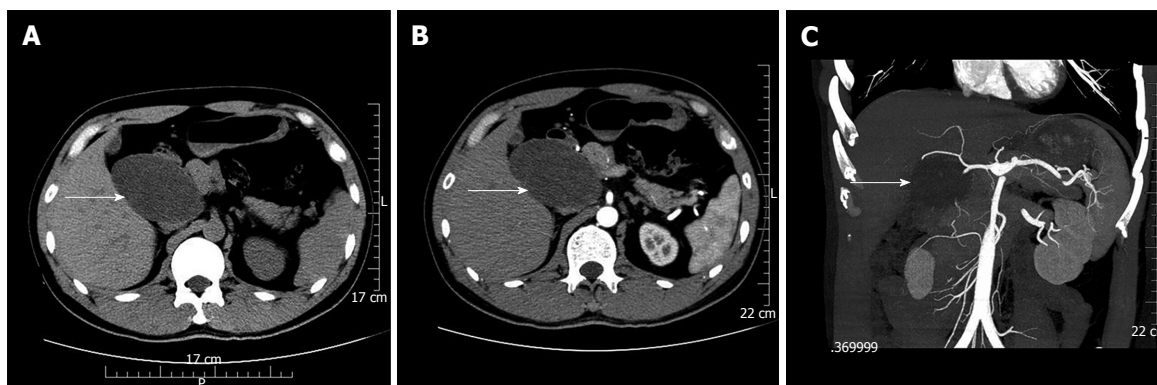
Computed tomography findings. A: An unenhanced computed tomography (CT) scan showed an 8.2 cm × 5.1 cm well-defined cystic and solid mass (arrow) above the pancreatic head and adjacent to the common hepatic artery; B: On contrast-enhanced CT, the mass (arrow) showed no obvious enhancement; C: CT angiography showed that the tumor blood supply (arrow) was probably from branches of the pancreaticoduodenal artery.
